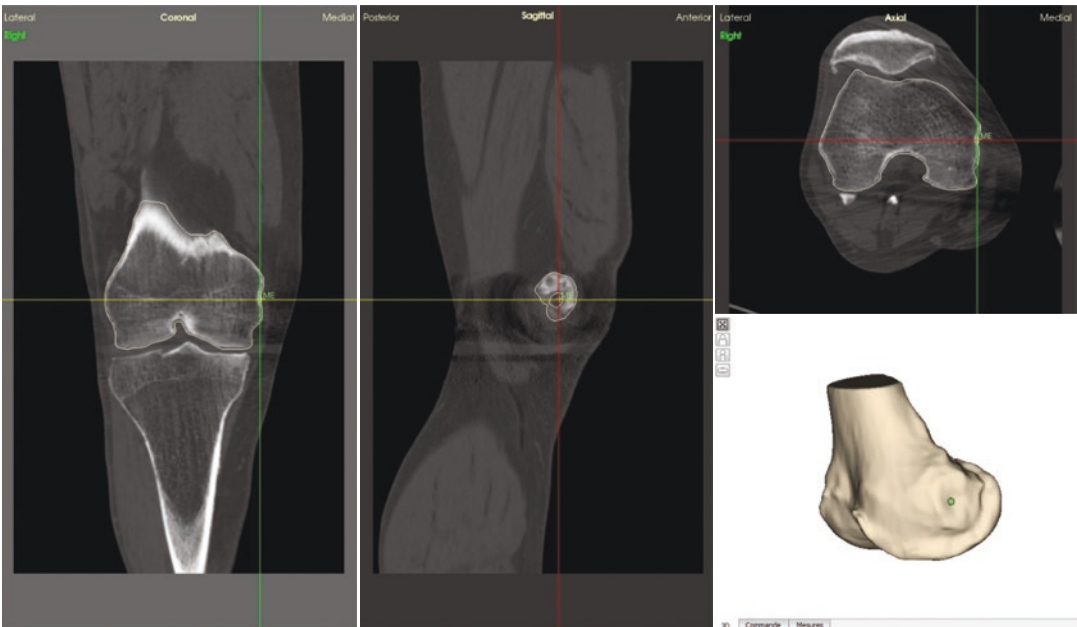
CT slices of a patient's knee and the most medial point of the medial femoral epicondyle selected
